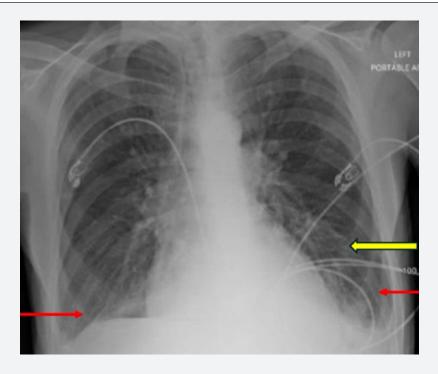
Chest X-ray: Small bilateral pleural effusions with left basilar consolidation Red arrows indicate pleural effusions. Yellow arrow indicates consolidation.
